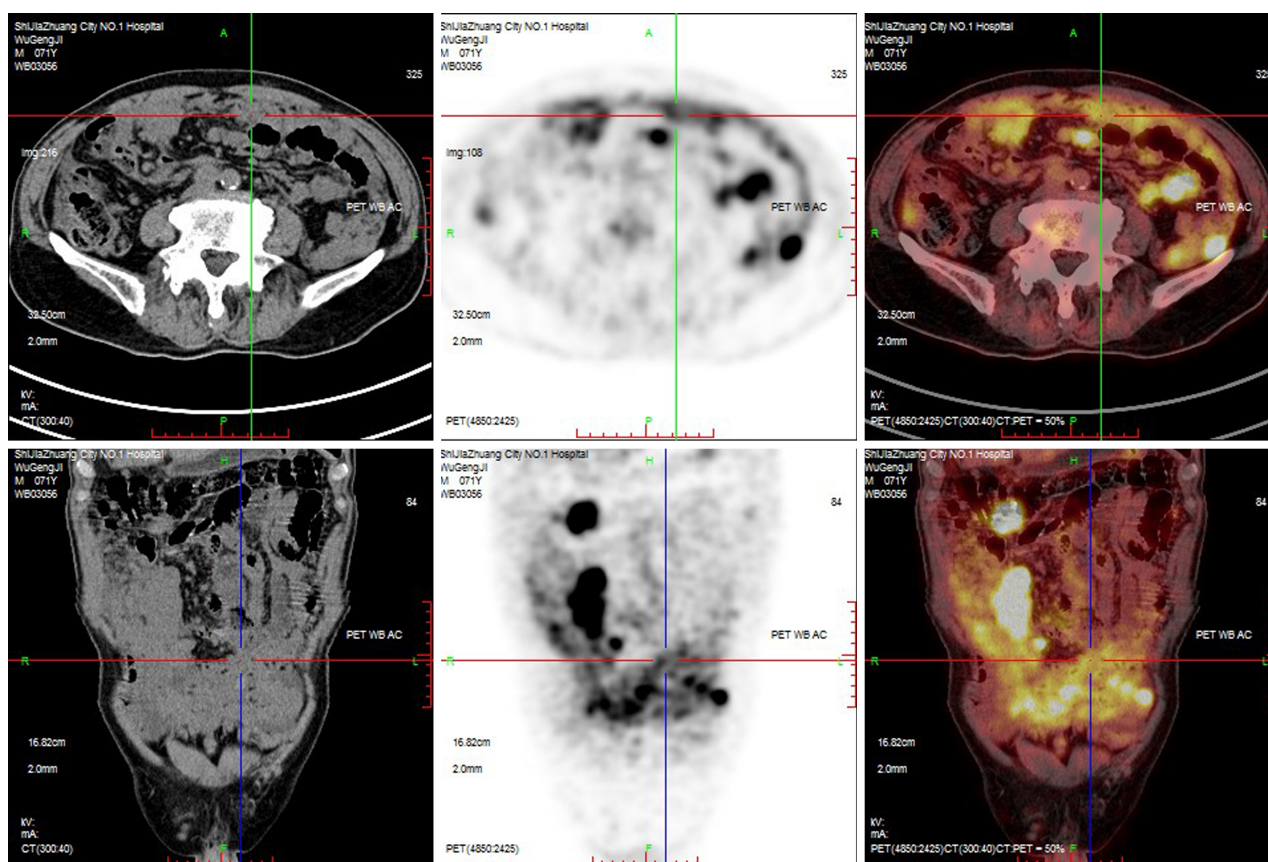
Abdominal computed tomography scanning. It shows that the tumor is of heavy load and diffused in the abdominal cavity.
